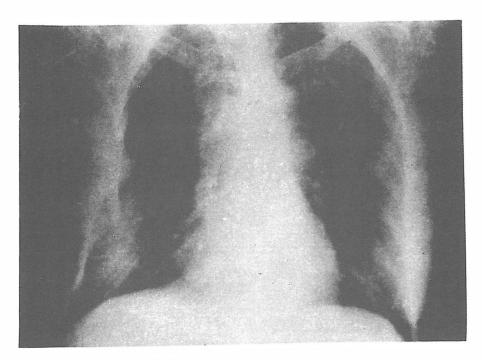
Chest X-ray revealing osteoporosis.
